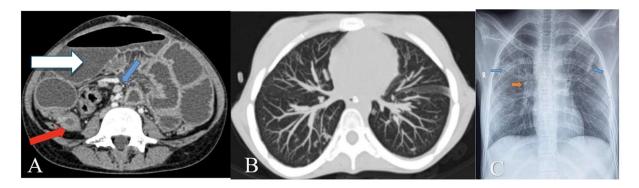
Chest radiograph in abdominal TB (A): Abdominal CECT (axial section) showing circumferential, symmetrical, enhancing wall thickening in ileo-cecal junction (red arrow) causing dilatation of proximal ileal loops showing airfluid level (white arrow) suggestive of small intestinal obstruction. Mesenteric node with central hypodensity and peripheral enhancement also seen (blue arrow). (B) Lung window (axial section) MIP (Maximum Intensity Projection) through the upper abdomen shows tree in bud nodules in right lower lobe (yellow arrow). (C) Chest PA radiograph showing fibro-infiltrative opacities (blue arrow) in right and left upper zones; and right hilar node (orange arrow), suggestive of pulmonary TB. Laboratory investigations were non-confirmatory, but the patient recovered on empirical treatment for Disseminated TB.
